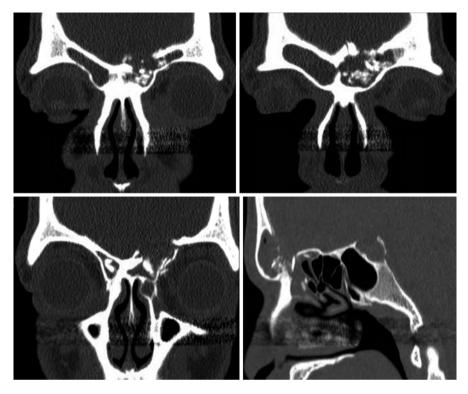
Coronal and sagittal CT scans of a patient with severely comminuted posterior table fracture and CSF leak
